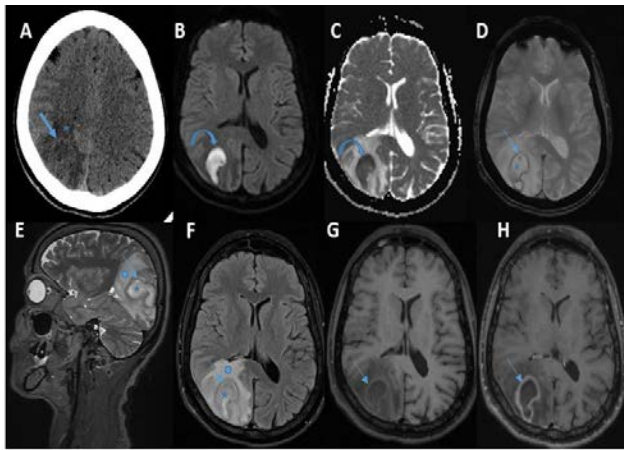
In the right parieto-occipital region, an irregular space occupying lesion was seen A. Axial CT head shows a hypodense center with hyperdense rim (arrow) surrounded by vasogenic edema (star). B & C the lesion shows diffusion restriction centrally (curved arrow). D: The wall of the lesion shows blooming on SWI sequence (arrow). E & F : The lesion shows high signal centrally on sagittal T2 & axial FLAIR sequences (star) and rim of dark signal (arrow) with surrounding vasogenic edema (circle). G: The rim of the lesion is hyperintense on T1 with central hypointense signal. H: Post contrast administration, the lesion shows smooth peripheral enhancement
